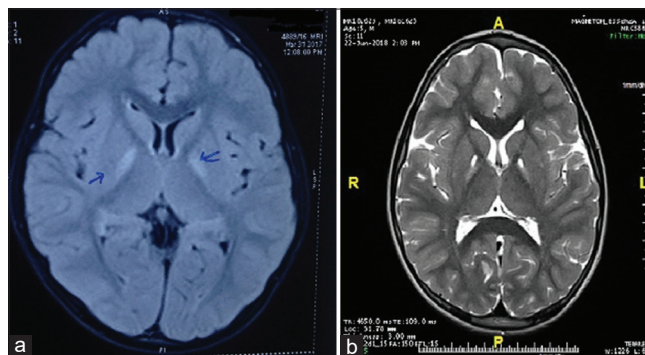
MRI brain showing bilateral pallidus hyperintensity in (a) elder sib—FLAIR. (b) younger sib—T2 sequence
